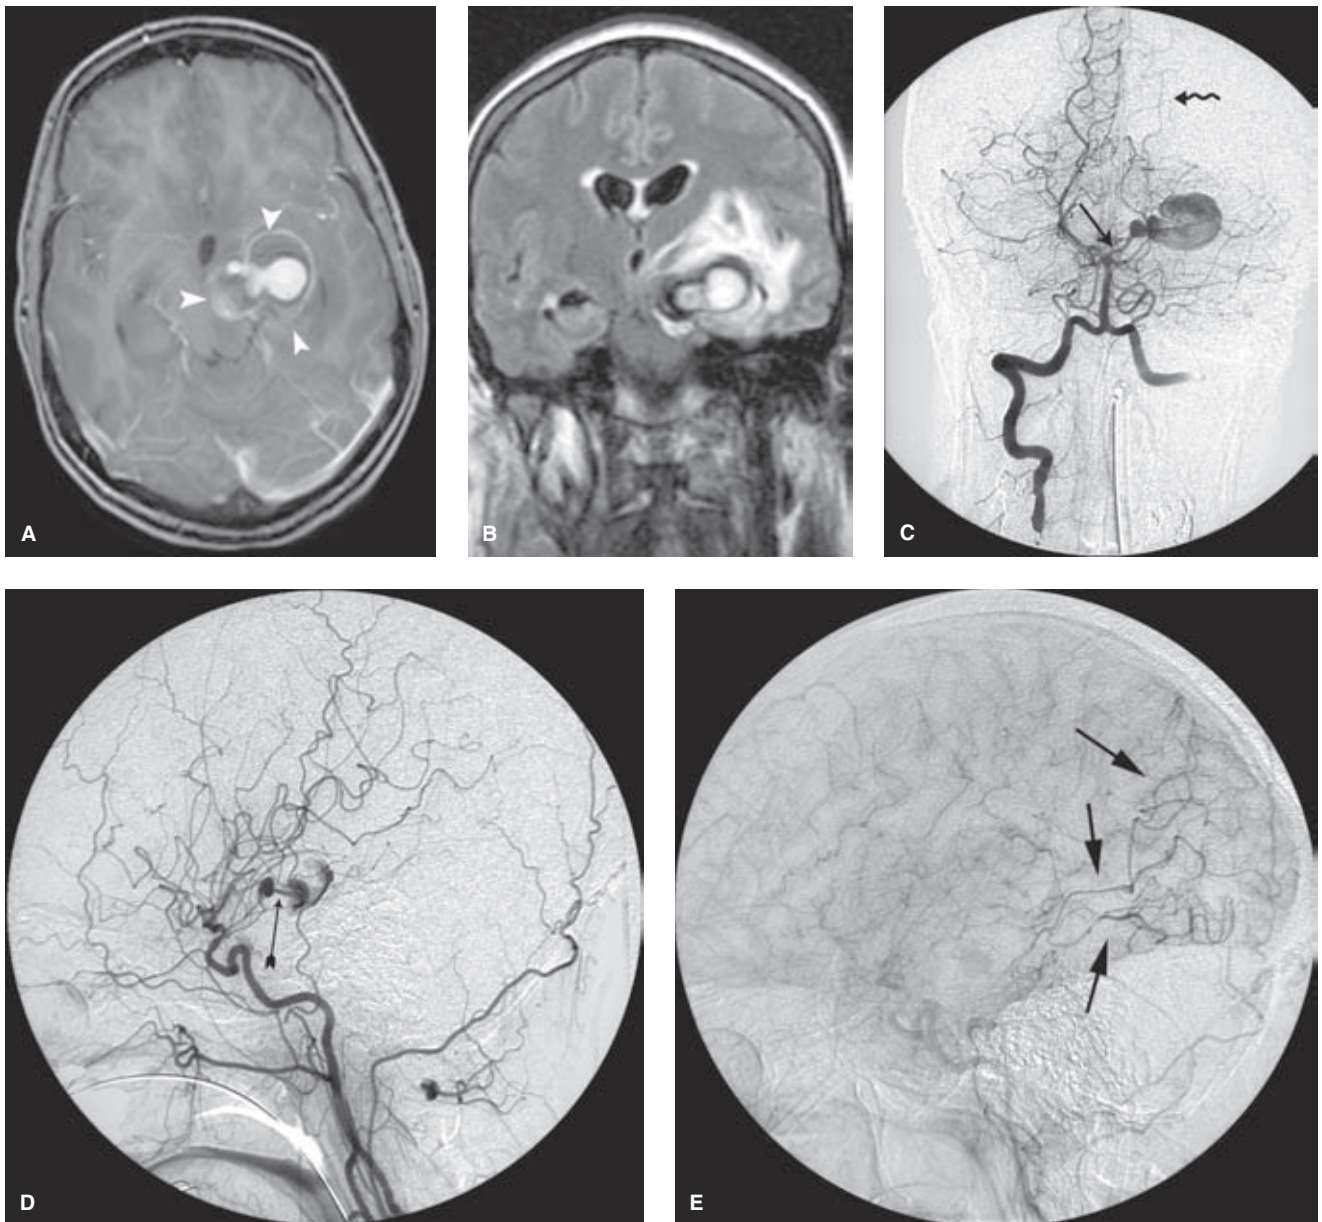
(A–E) Dissecting aneurysm of the left posterior cerebral artery I. A young adult presented with right-sided hemiplegic symptoms, oculoplegic disturbance, and a visual field cut. The T1 gadolinium-enhanced MRI (A) and FLAIR sequence (B) demonstrate that the enhancing component of the large aneurysm in the perimesencephalic cistern is only a fraction of the overall aneurysm size (*arrowhead* in A). There is considerable surrounding edema and mass effect in the brainstem, thalamus, and internal capsule accounting for her symptoms. The Townes view of the posterior circulation (C) shows elevation and stretching (*straight arrow* in C) leading to filling of a complex multilobulated aneurysm, beyond which there is slow filling of the distal posterior cerebral artery territory (*wavy arrow*). The aneurysm is also seen on the left common carotid artery injection (D), where a pronounced jet of inflow to the distal aneurysm (*arrow* in D) is seen. This jet pattern probably accounts for the bizarre multilobulated and partially thrombosed appearance of the aneurysm. The compromised flow in the distal posterior cerebral artery is a commonly seen feature of long-standing dissecting aneurysms, and this can work to the patient's advantage in that this compromise can encourage development of pial–pial or other collaterals to the distal territory over time. In (E), the patient is undergoing a temporary balloon occlusion of the left posterior cerebral artery, while a simultaneous contrast injection is performed in the left common carotid artery. The parenchymal phase of the injection shows prominent retrograde collaterals (*arrows* in E) to the posterior cerebral artery territory, arguing that the patient should be able to tolerate an endovascular occlusion of the dissected segment of vessel as definitive therapy for this aneurysm.
